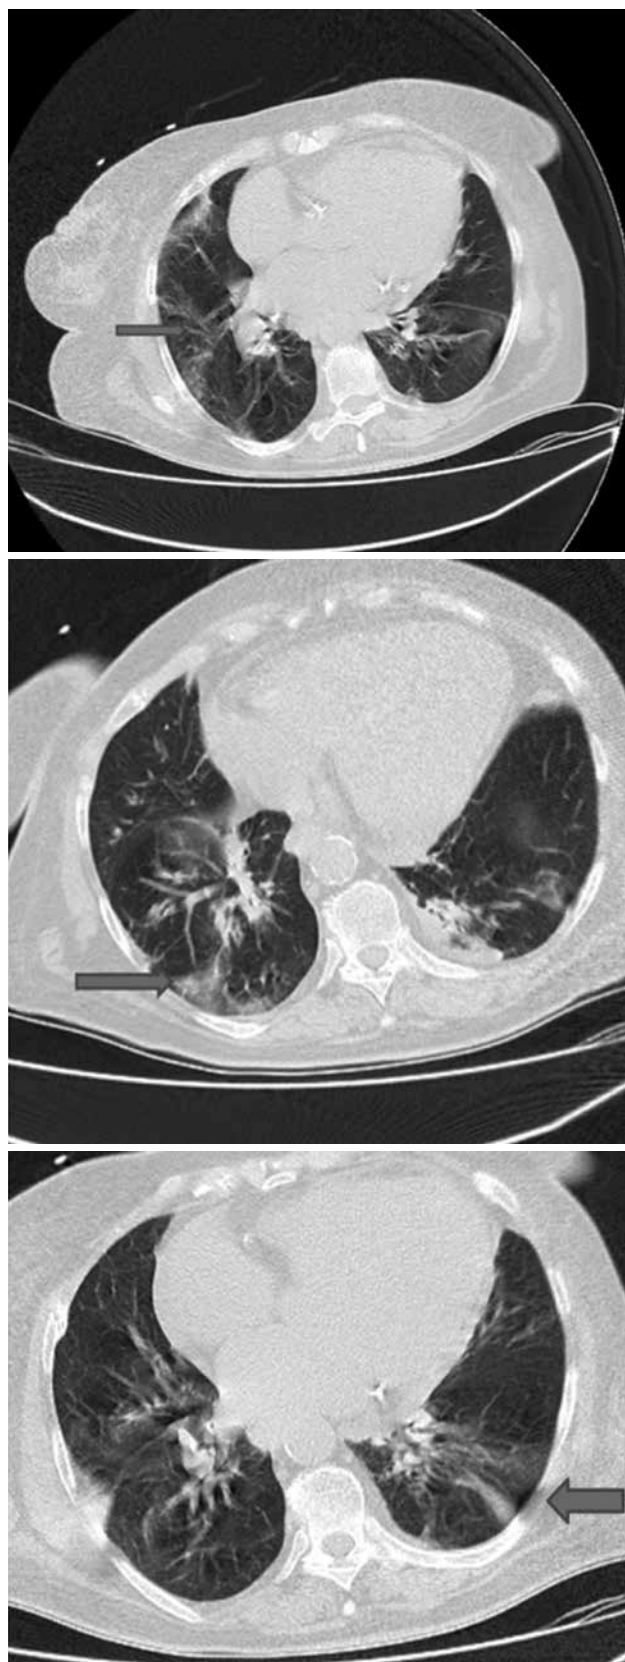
Bilateral ground glass opacities, significant parahilar opacities, bronchovascular irregularities, pleural and paranchimal fibrosis, small pleural effusions were seen in thorax CT of the patient.
